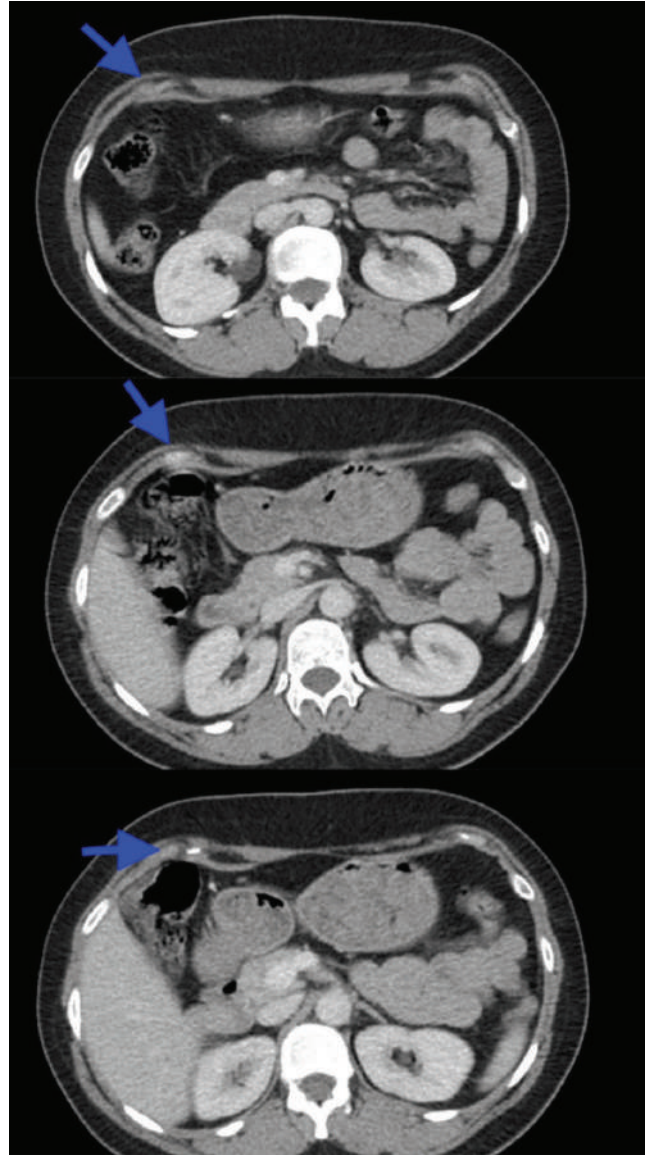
Computed tomography image.
